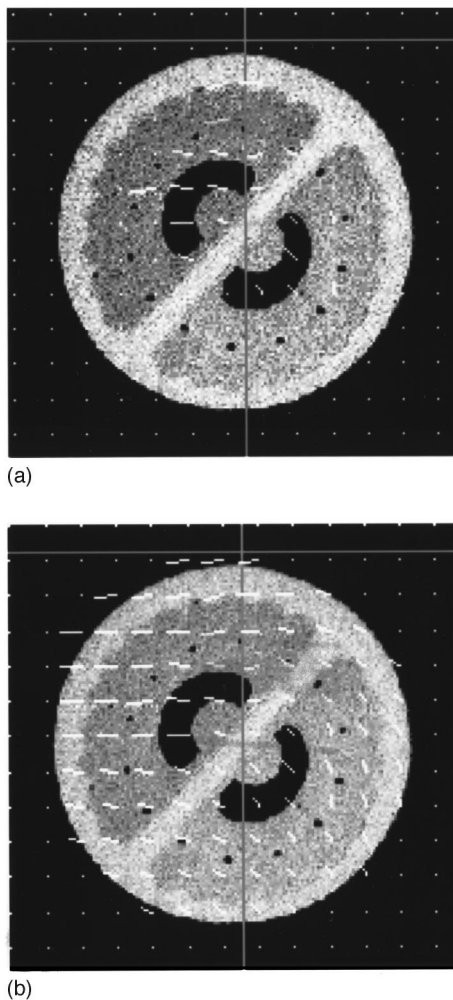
Deformation grid superimposed on the nondeformed MRI (16×16 subset of 64×64 nodes displayed). (a) Grid with initial deformation vectors applied. (b) Deformation grid after propagation/relaxation of the initial deformation to the other nodes.
